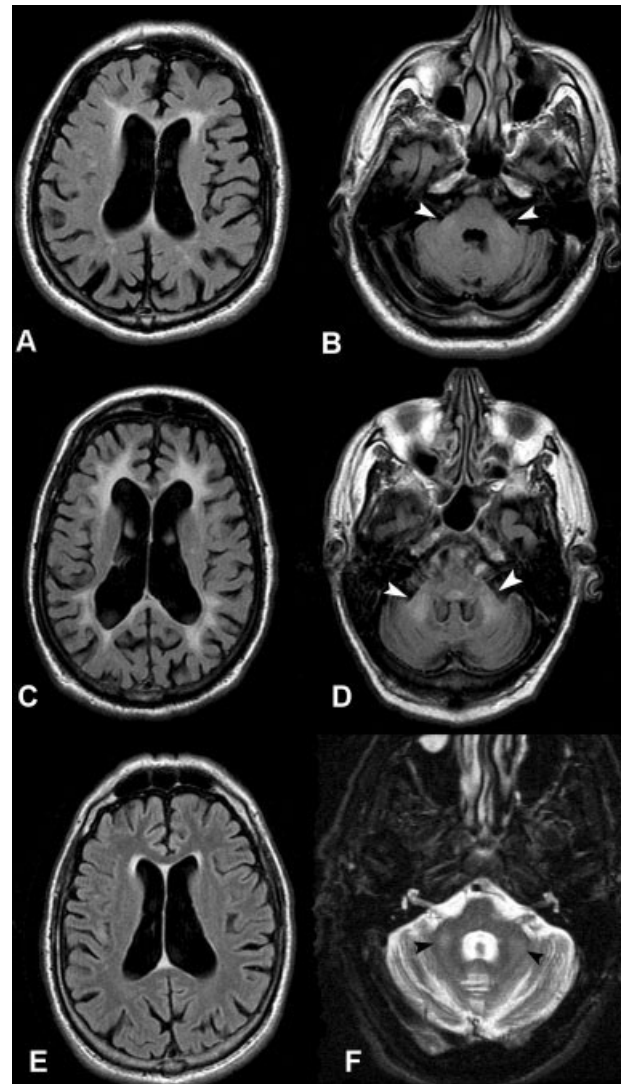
Axial FLAIR images: in Patient II-8, (A) cortical and subcortical atrophy associated with hyperintense lesions in the periventricular white matter, and (B) in the posterior fossa, a mild lesion in the MCPs (middle cerebellar peduncles; arrowheads); in Patient II-5, (C) cortical and subcortical atrophy associated with confluent hyperintense lesions in the periventricular white matter, and (D) in the posterior fossa, hyperintense lesions in MCPs (arrowheads); in Patient II-6, (E) cortical and subcortical atrophy. Axial T2-weighted image in Patient II-6 (F) demonstrates MCP signal abnormalities (arrowheads), not evident on FLAIR images (not shown). Axial spin echo T1-weighted: TR = 500 ms, TE = 9 ms, slice thickness = 5 mm, matrix = 256 × 192, NEX = 2, FOV = 24 × 24 cm²; axial fast spin echo T2-weighted: TR = 4,500 ms, TE = 83 ms, slice thickness = 5 mm, matrix = 320 × 224, NEX = 2, FOV = 24 × 24 cm²; axial FLAIR images: TR = 10,000 ms, TE = 104.5 ms, TI = 2,100 ms, slice thickness = 5 mm, matrix = 256 × 224, NEX = 1, FOV = 24 × 24 cm²; MRI 1.5 T equipment, Signa Horizon LX 8.2, General Electric, Milwaukee, WI.
